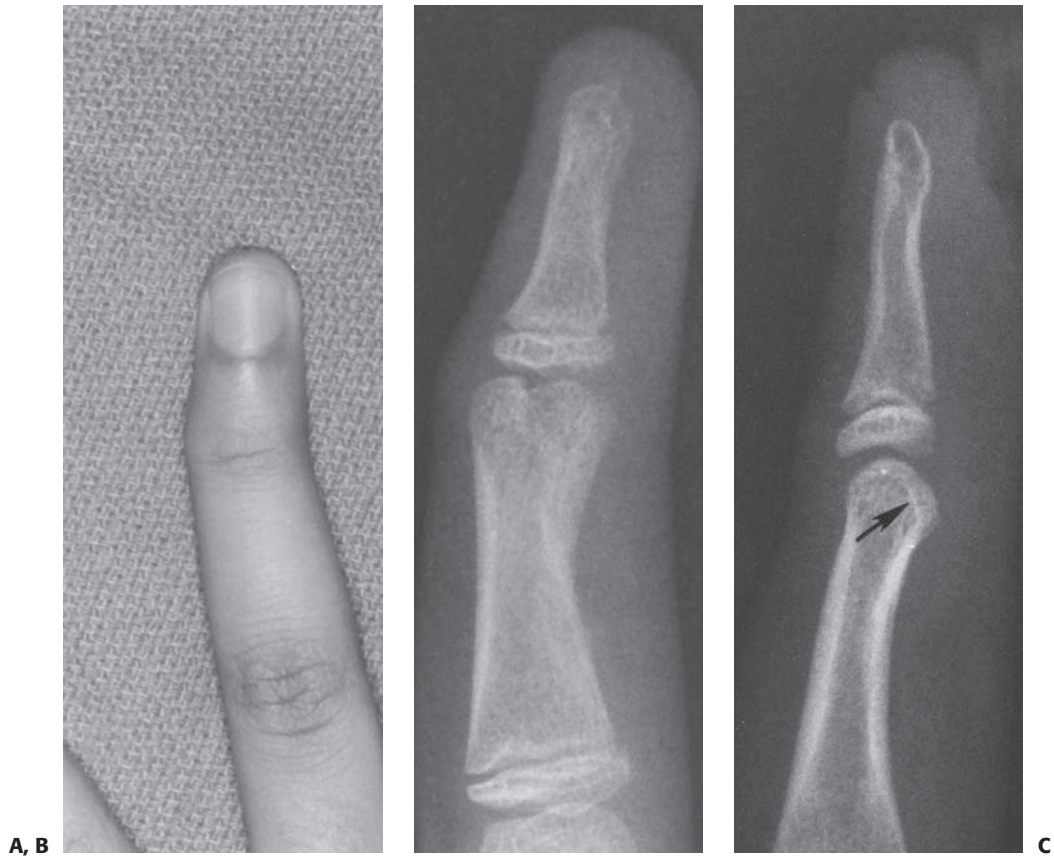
A: A 13-year-old boy with malunion of the ring finger middle phalanx articular surface. B, C: Radiographs reveal slight malunion of the radial condyle with mild intra-articular incongruity. The lateral view suggests a double density shadow (*arrow*). The flexion and extension motion of the digit was normal, and reconstruction was not recommended.
